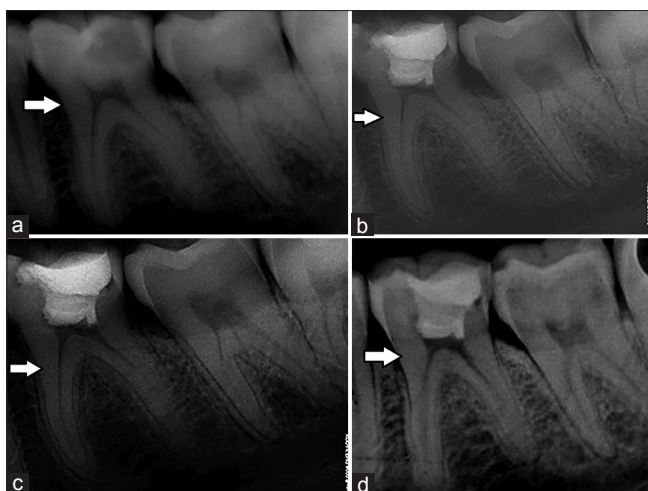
Radiographic evaluation of a case with platelet-rich fibrin pulpotomy (tooth #36). (a) Preoperative radiograph. (b) Immediate postoperative radiograph after performing pulpotomy. (c) Six months follow-up radiograph. (d) One-year follow-up radiograph
